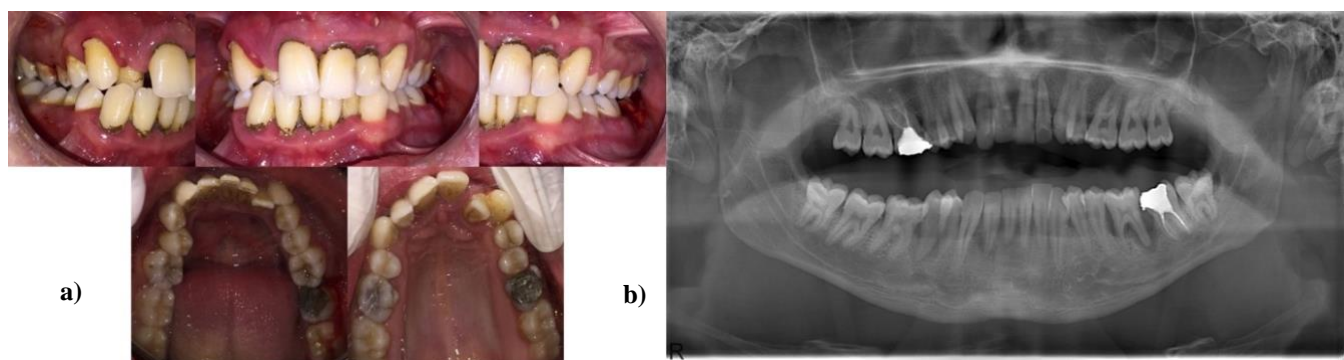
a) Clinical photographs, b) radiographical view of the case (baseline)
